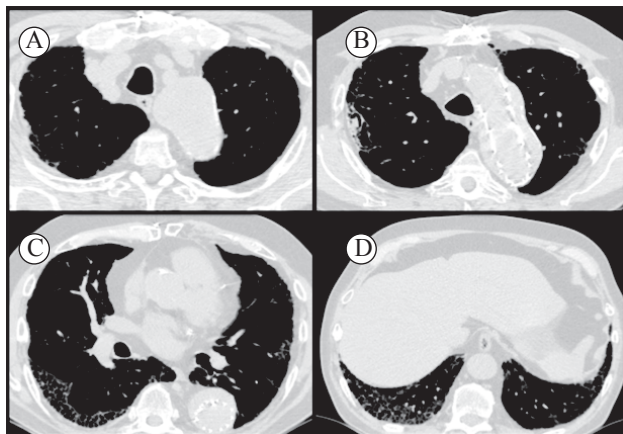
shows CT scan of the chest of a 67-year-old female patient with combined pulmonary fibrosis and emphysema, showing centrilobular and paraseptal emphysema in the upper lobes (A and B), as well as ground-glass opacities, traction bronchiectasis, and honeycombing in the lower lobes (C and D). Note an aspergilloma in one of the paraseptal bullae in the right upper lobe (white arrow, in B)
